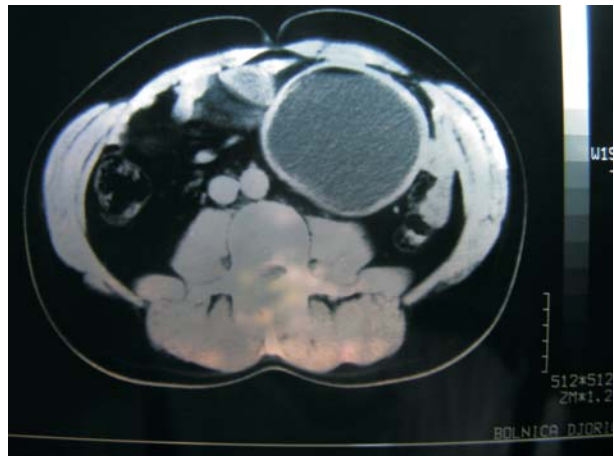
CT scan presenting mesenteric cyst
